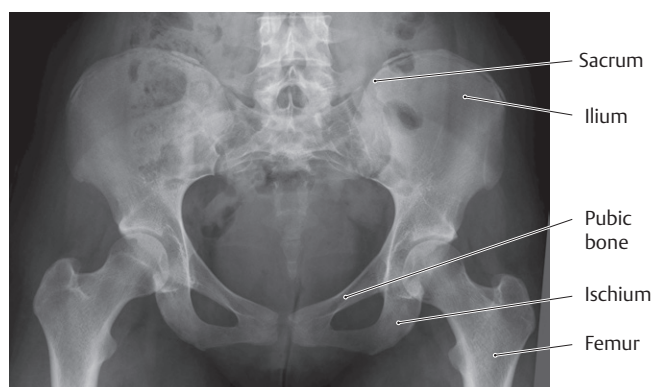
Radiograph of the pelvis in an adult
